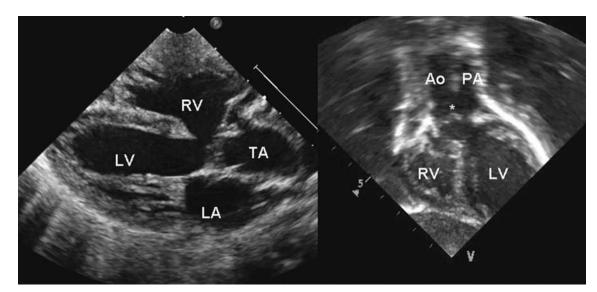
Truncus arteriosus. Parasternal long axis view (*left*) shows large truncal root (TA) overriding the ventricular septum receiving outflow from both the right ventricle (RV) and left ventricle (LV). Ascending aorta (Ao) and pulmonary artery (PA) arising directly from the proximal truncal root (*) are shown on the subcostal long axis view (*right*).
